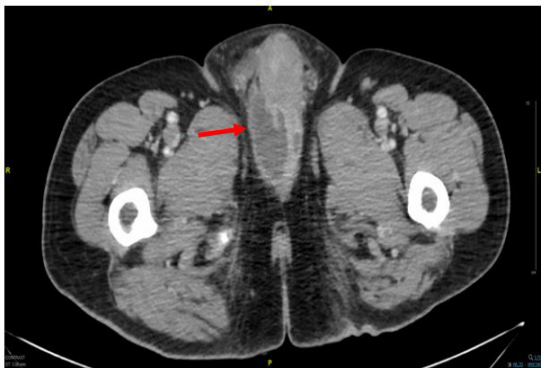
CT Scan: fluid collection, pressing the Corpus cavernosum (red arrow).
